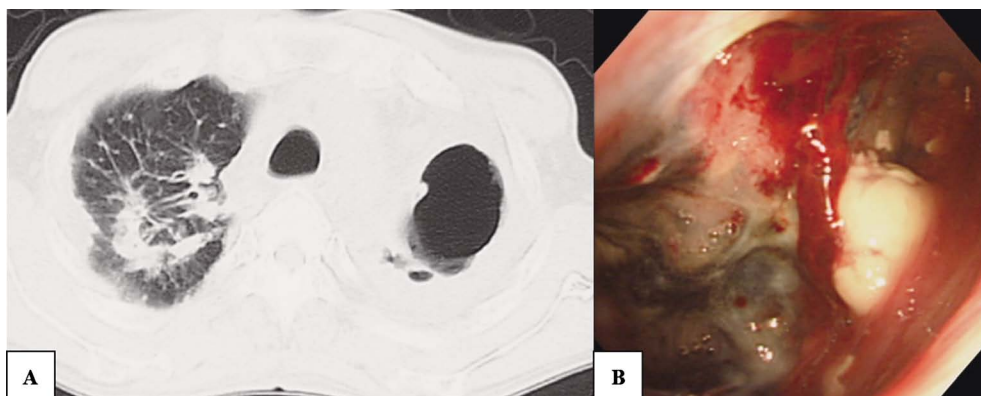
(A) Chest CT scan of case 2 on April 3, 2007 showing a thick-walled cavity in LUL and nodular lesions in RUL. (B) Bronchoscopic examination of the cavity showing an irregular black surface and white nodules with bleeding. LUL, left upper lobe.
